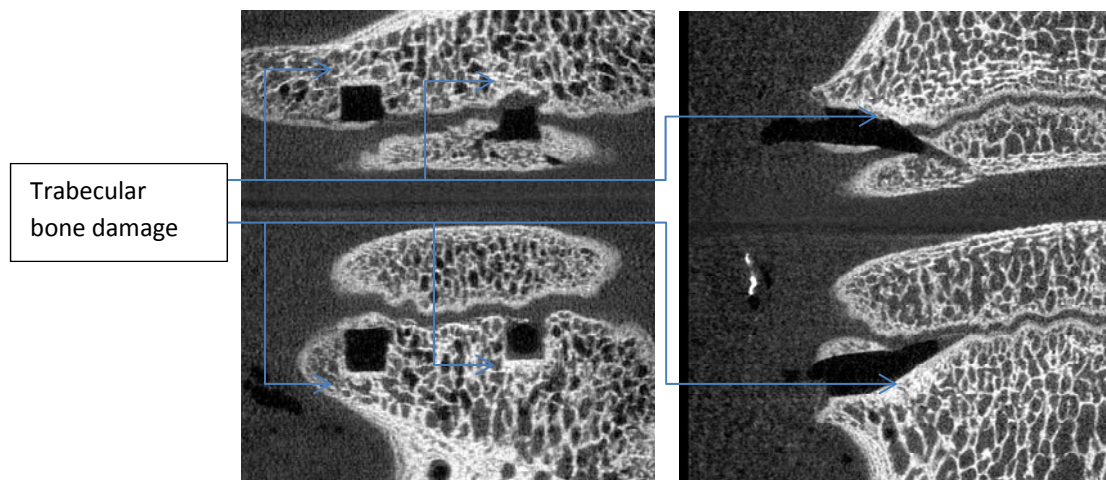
MICRO CT SHOWING STAPLE PRONG TRACKS HIGHLIGHTING SITE OF TRABECULAR BONE DAMAGE.
